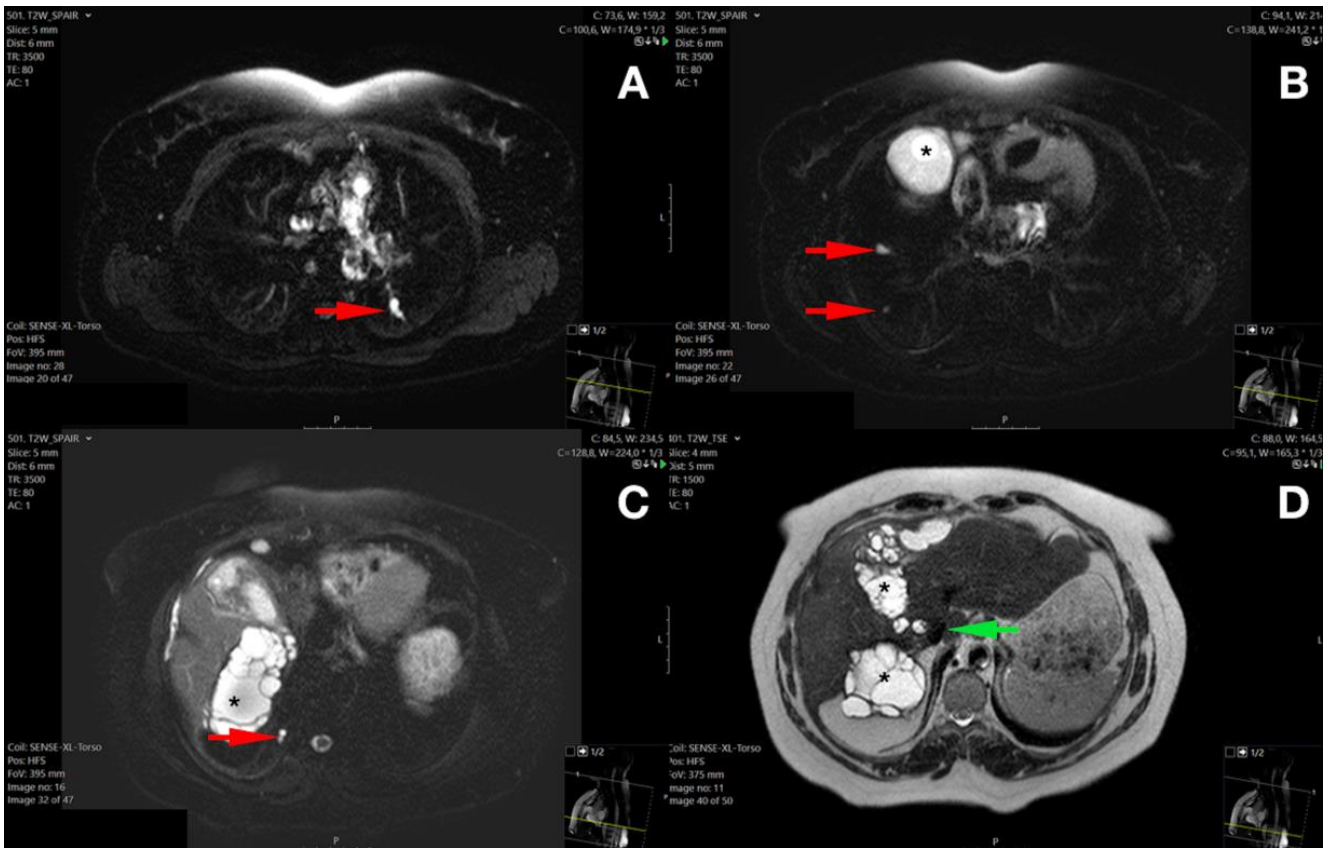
Axial, non-contrast enhanced CT images of the patient (before treatment). Red arrows: Cystic embolus mimicking peripheral nodules, Asterisk: Cystic lesion at the liver
